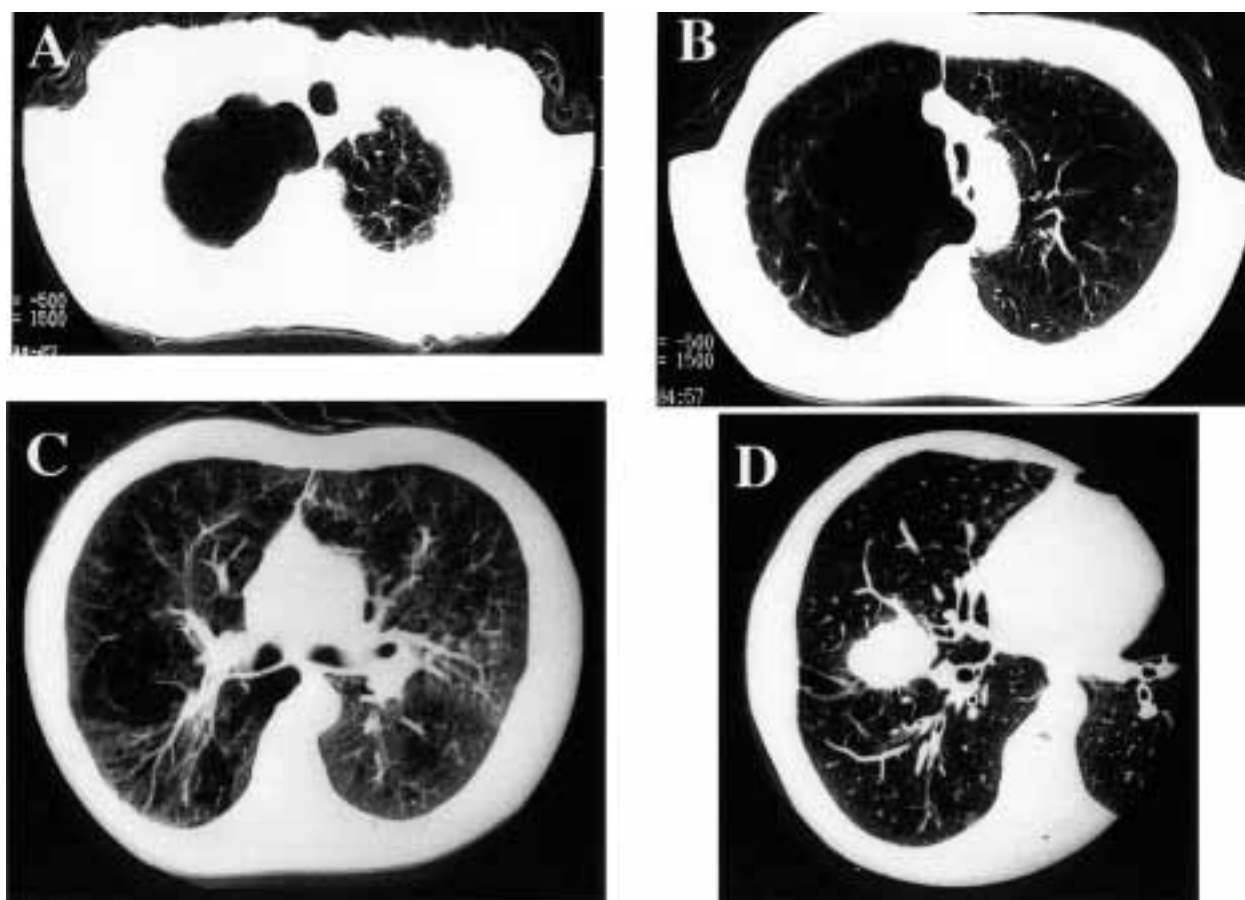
Preoperative chest CT (A, B, C) showed bilateral heterogeneous severe pulmonary emphysema with a giant bulla in the right upper lobe and revealed a tumor lesion in the right middle lobe (D).
